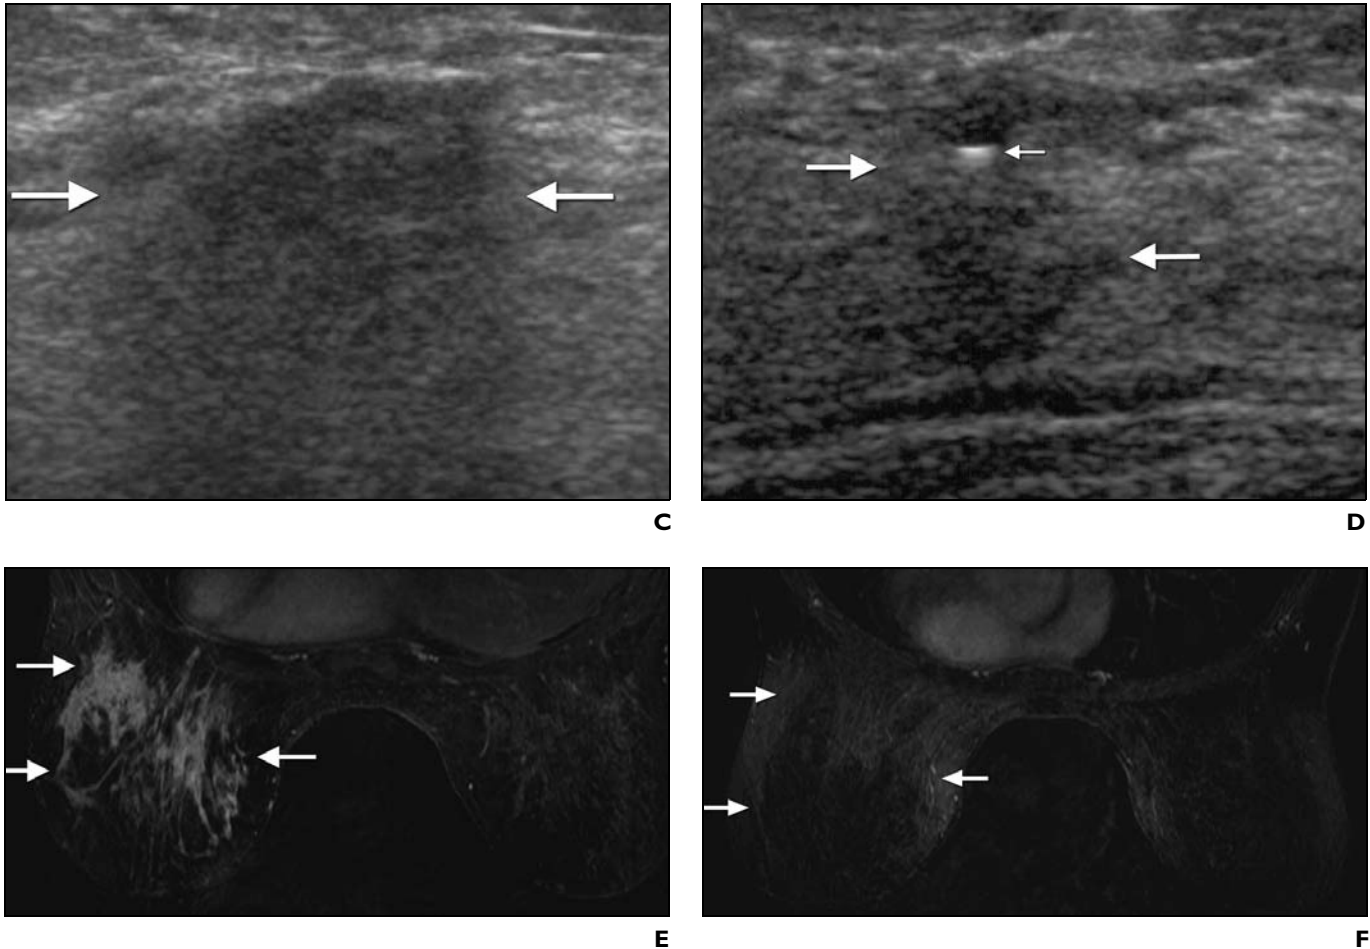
(continued)—46-year-old woman with left breast lump. After chemotherapy, patient had lumpectomy with pathology results showing dense sclerosis and no residual tumor. C, Sonogram obtained before chemotherapy shows irregular hypoechoic shadowing and 2.1-cm mass (arrows) in left breast at 2-o'clock position in transverse plane. D, Sonogram obtained after chemotherapy shows discrete residual mass (large arrows) in transverse plane. Micromark clip is present within mass (small arrow). E, Axial subtraction MRI obtained before chemotherapy shows extensive enhancement (arrows) in left breast. Before patient received chemotherapy, more tumor was detected on MRI (10 cm) than initially was suspected on basis of physical examination (3 cm), mammography (dense negative), or sonography (2.1 cm) findings. F, Axial subtraction MRI obtained after chemotherapy shows complete resolution of enhancement (arrows).
